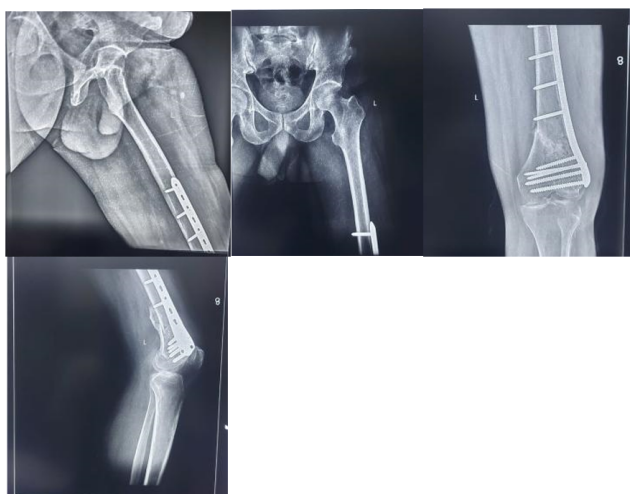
Follow up x-rays- 3 months
